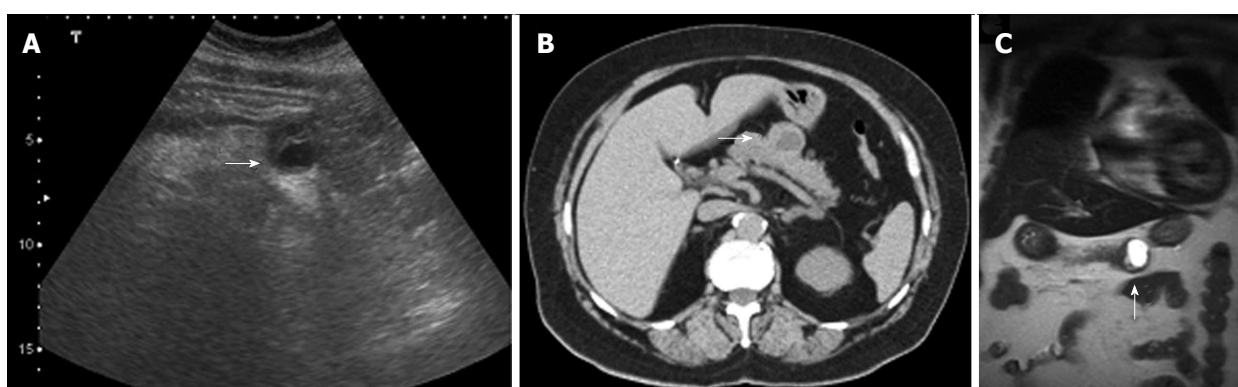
Pancreatic neuroendocrine tumor. Ultrasound images (A), axial unenhanced multidetector computed tomography and coronal magnetic resonance T2-weighted image show a round, heterogeneous mass, localized in the pancreatic body, with variable amounts of cystic-necrotic degeneration (arrows).
